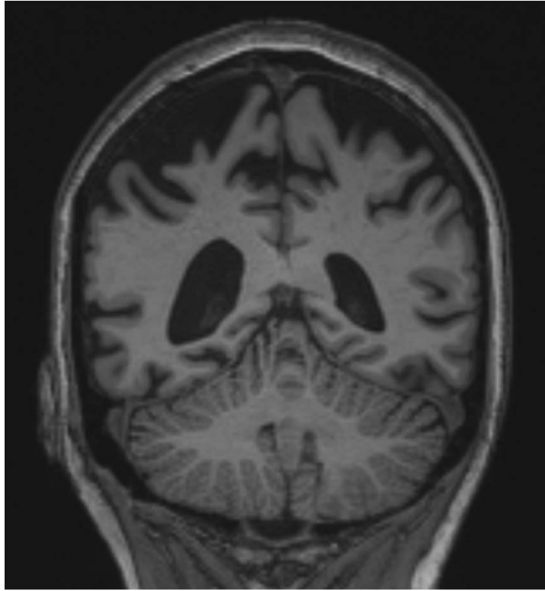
Coronal MRI of Case 3 showing severe bilateral parietal cortical atrophy, consistent with the pattern of atrophy typically seen in the PCA syndrome.
